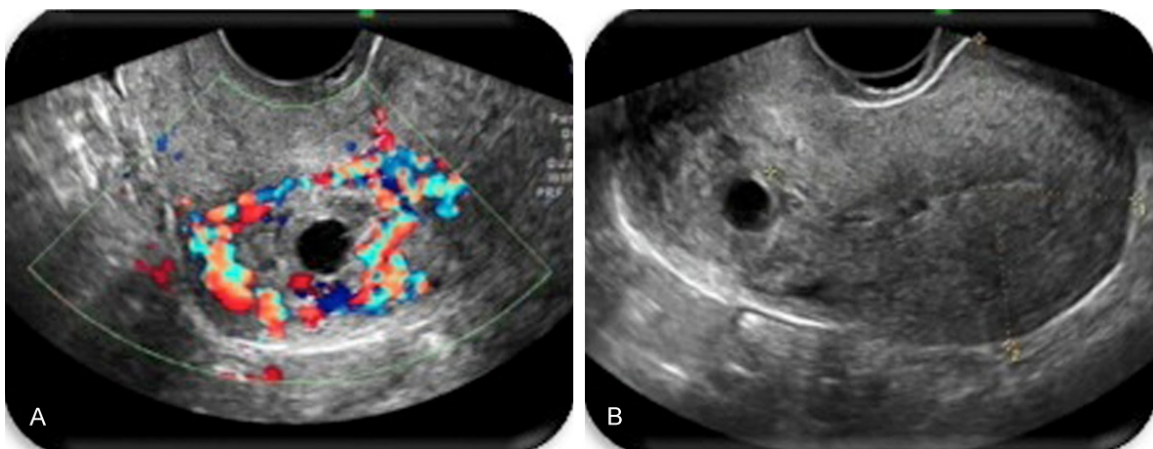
Ultrasound scans revealed the gestational scar (B) with increased blood flow (A) surrounded.
